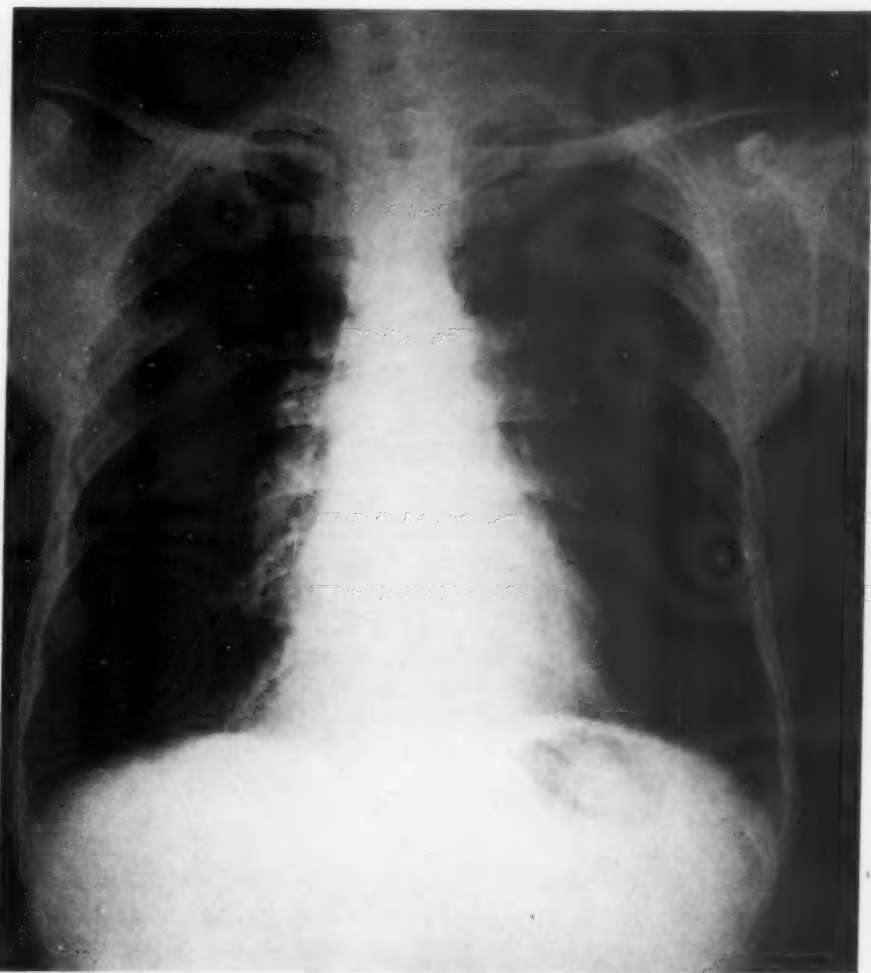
(Case 1.) Roentgenogram taken September 5, 1939. Both lung fields clear. Cardiac silhouette normal in size and configuration.
